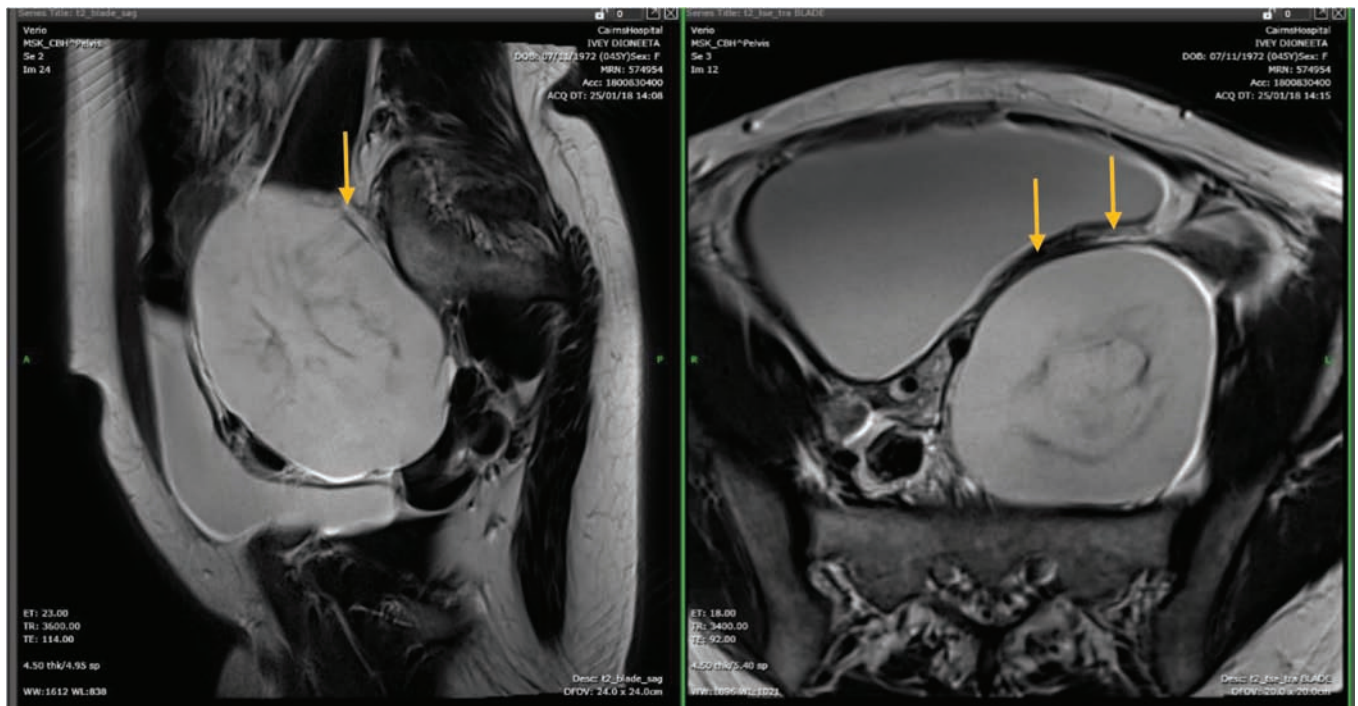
Magnetic resonance T2-weighted images showing the mildest delineation making this a retroperitoneal lesion.
